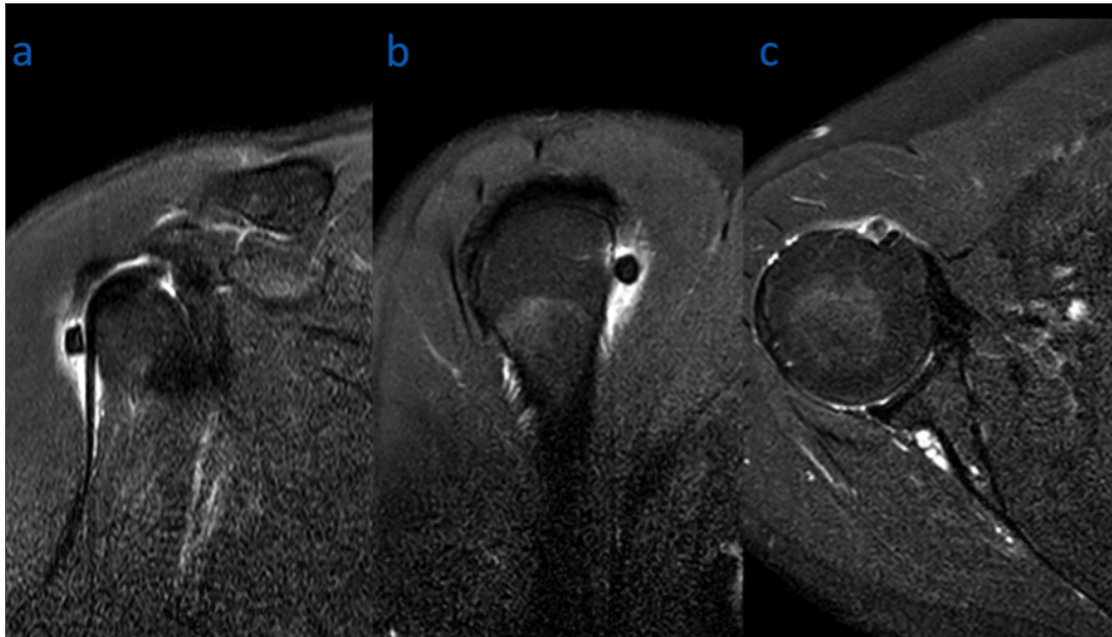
Calcific tendinitis findings on MRI. a) MRI coronal T2 sequence showing calcific tendinitis and intact biceps tendon; b) MRI sagittal T2 sequence showing calcific tendinitis; c) MRI axial T2 sequence showing calcific tendinitis and glenohumeral joint compliance.
